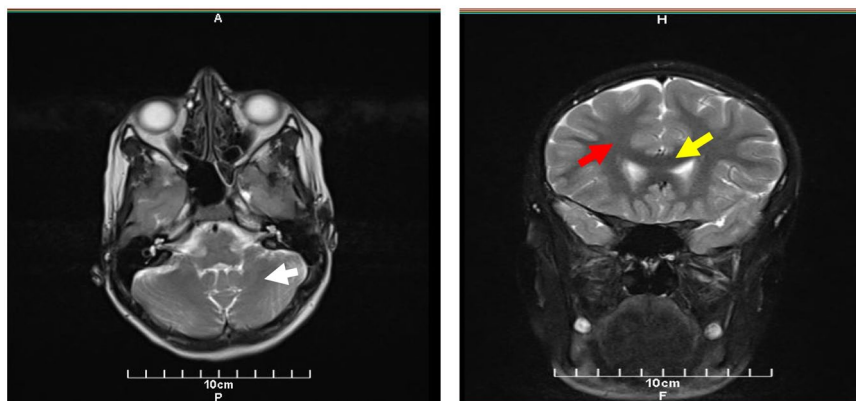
Magnetic resonance imaging showing pan-cerebellar atrophy (white arrow), thinning of corpus callosum (yellow arrow), and loss of white matter (red arrow).
